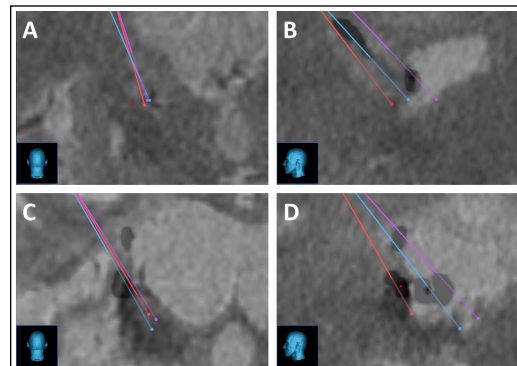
Air can accumulate in stroke cavity and along injection tract. Fused postoperative CT and MRI are shown for two patients (A & B, C & D).
